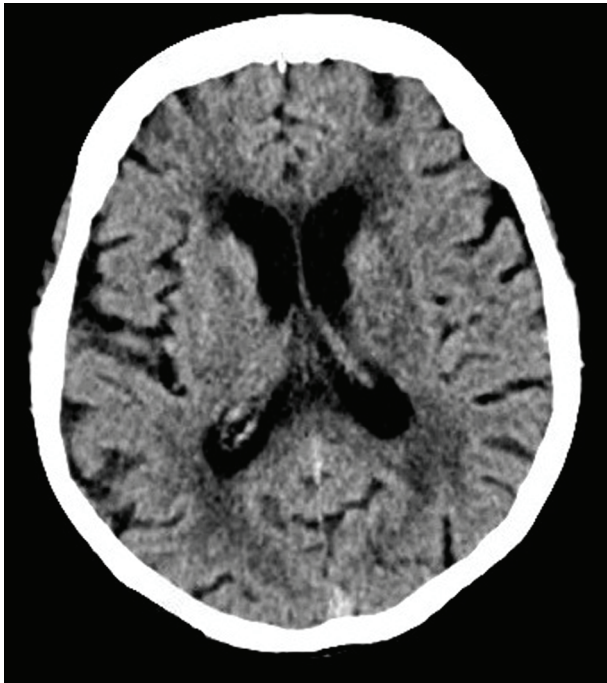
CT of head done 1 week before admission showing no hemorrhage.
